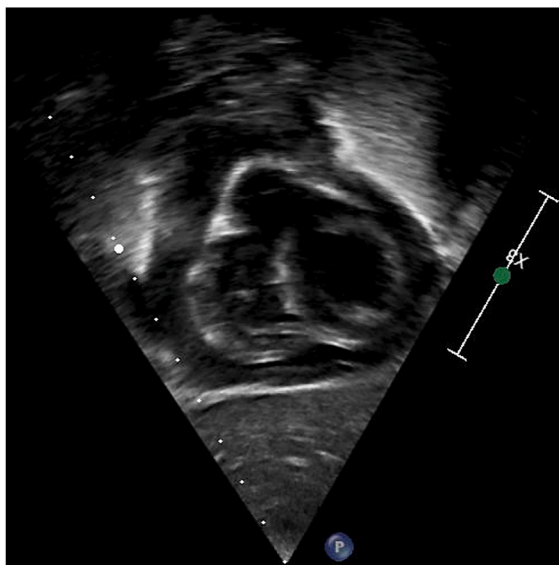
Day 3 on extracorporeal membrane oxygenation; echocardiography with pericardial effusion.
